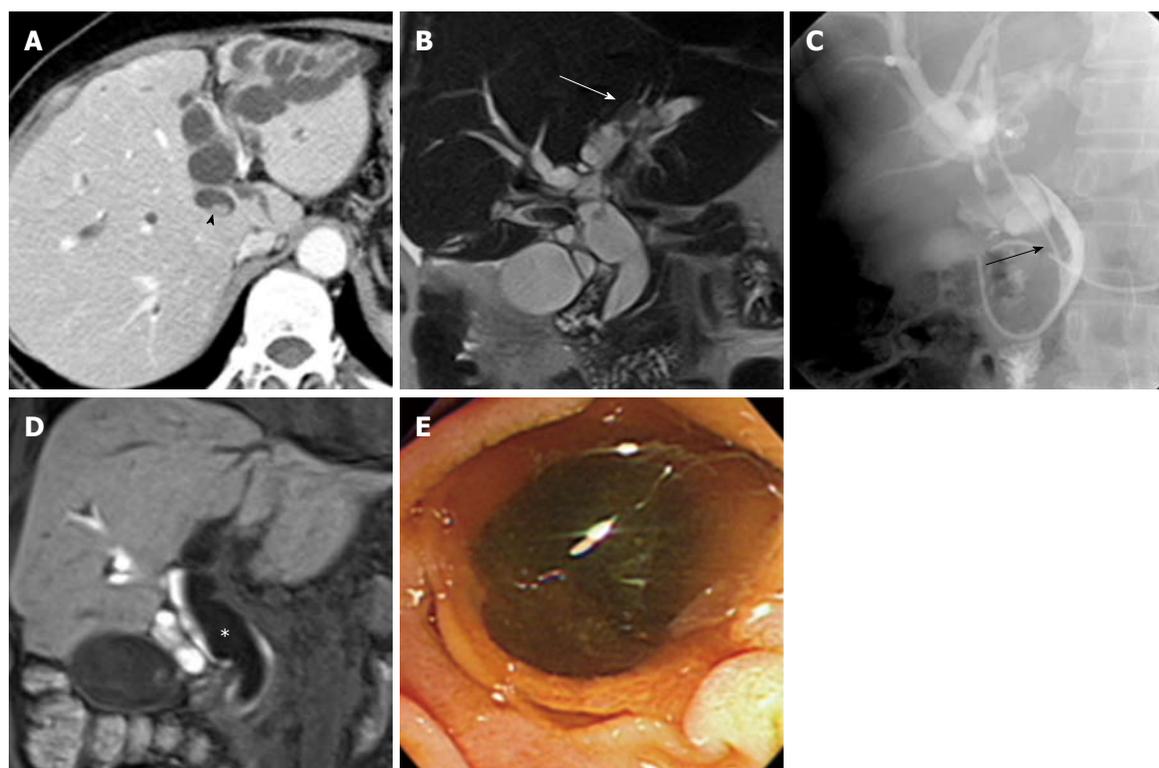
Intraductal papillary mucinous neoplasm of the bile duct in a 58-year-old woman. A: Contrast-enhanced CT image shows severe dilatation of the left intrahepatic ducts without visible intraductal mass. Note a small stone in the dilated intrahepatic duct (arrowhead); B: Coronal T2-weighted RARE MR image shows dilatation of the intrahepatic and extrahepatic ducts. Note the hypointense intraductal mass (arrow) in the left intrahepatic duct; C: Endoscopic retrograde cholangiogram image shows a filling defect (arrow) within the marked dilated extrahepatic bile duct, due to mucin; D: Coronal gadobenic acid-enhanced T1-weighted MR image obtained at 60 min post-injection shows contrast-filled bile duct with an elongated, low signal intensity lesion (asterisk), which represents mucin; E: Endoscopy image reveals mucin leaking from the papilla. CT: Computed tomography; RARE: True rapid acquisition with relaxation enhancement; MR: Magnetic resonance.
